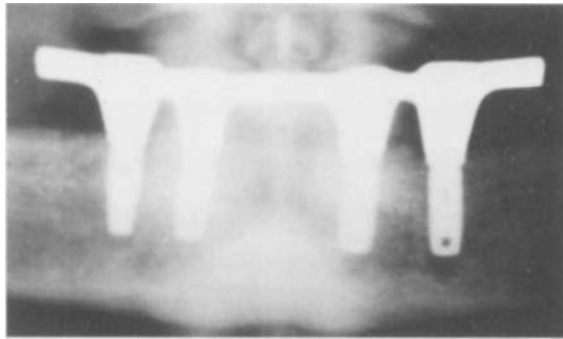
■ Postoperative radiograph of a completed case.
